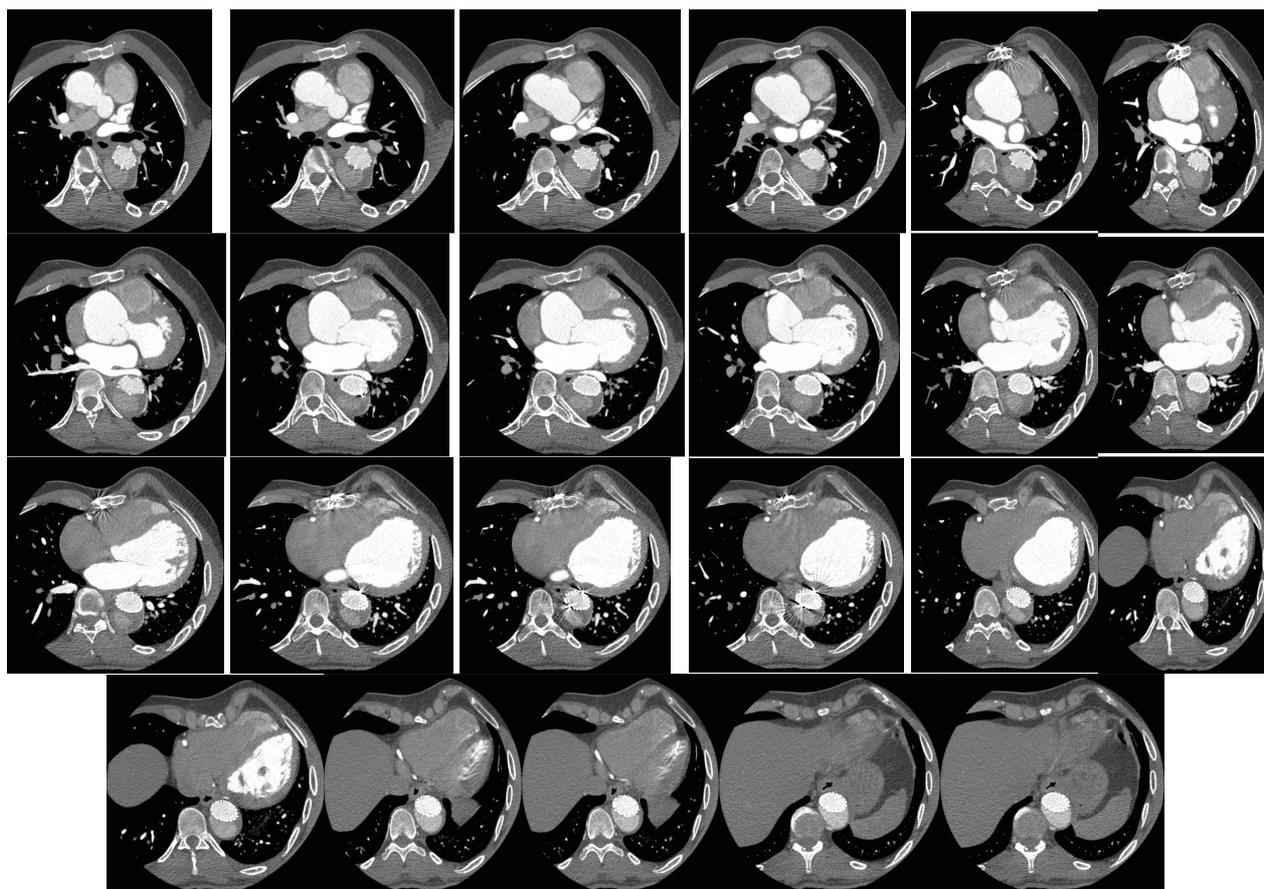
Computed tomography angiography after stent implantation (Continue)
